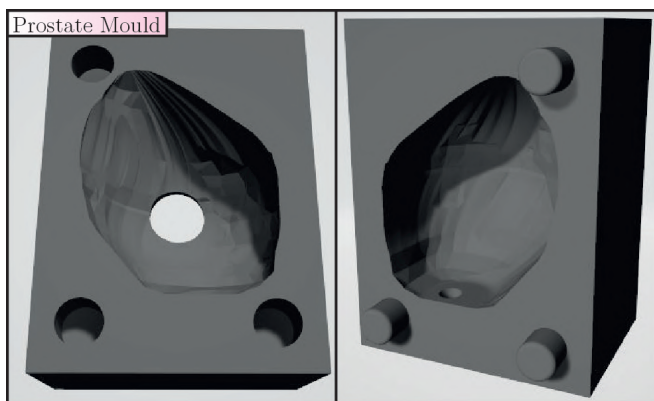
A prostate mould based on patient data from magnetic resonance images used to create a gelatin prostate.
